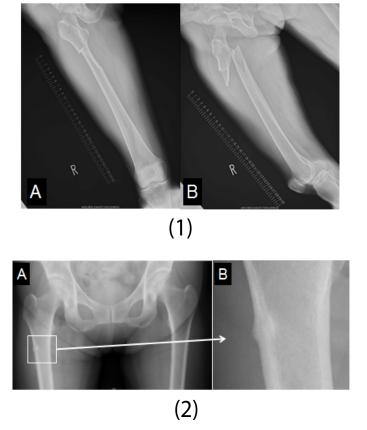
The plain radiograph showed substantial transverse subtrochanteric fracture with a medial spike.
